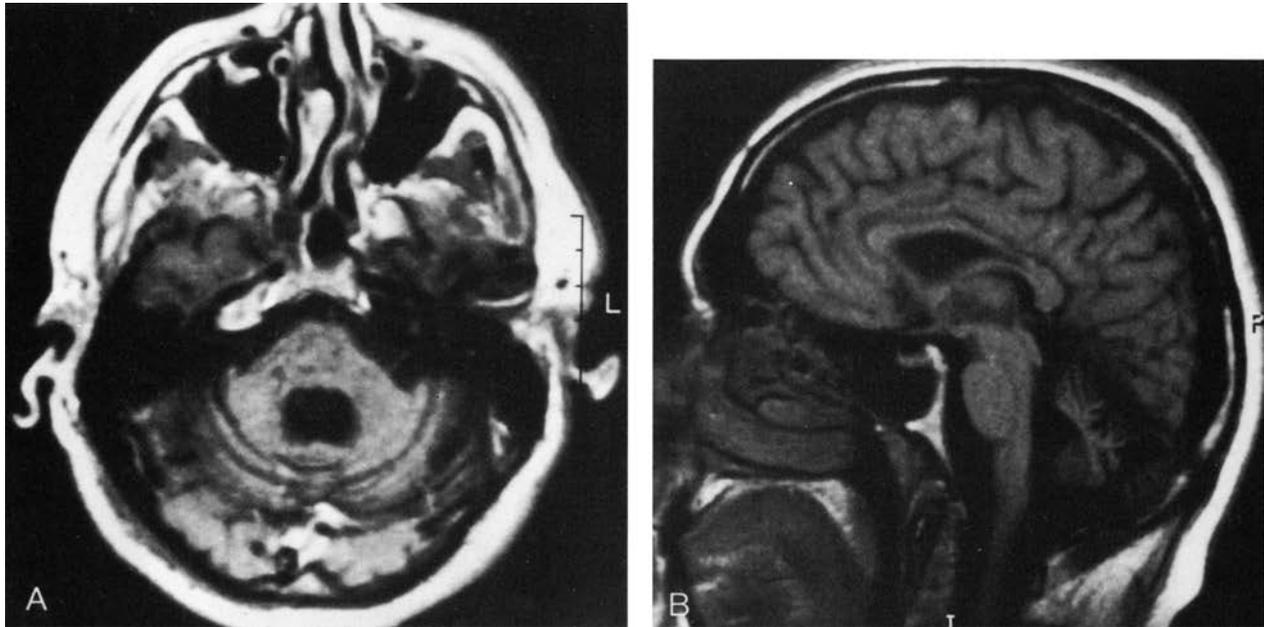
T1-weighted magnetic resonance images from a 42-year-old man with Hodgkin's disease and paraneoplastic cerebellar degeneration demonstrating features of cerebellar atrophy. *A*, The axial image shows enlargement of the fourth ventricle and widening of the cerebellar sulci. *B*, The sagittal image shows diffuse atrophy of the cerebellum. (From Hammack J, Kotanides H, Rosenblum MK, et al. Paraneoplastic cerebellar degeneration. II. Clinical and immunologic findings in 21 patients with Hodgkin's disease. *Neurology* 1992;42:1938–1943.)
